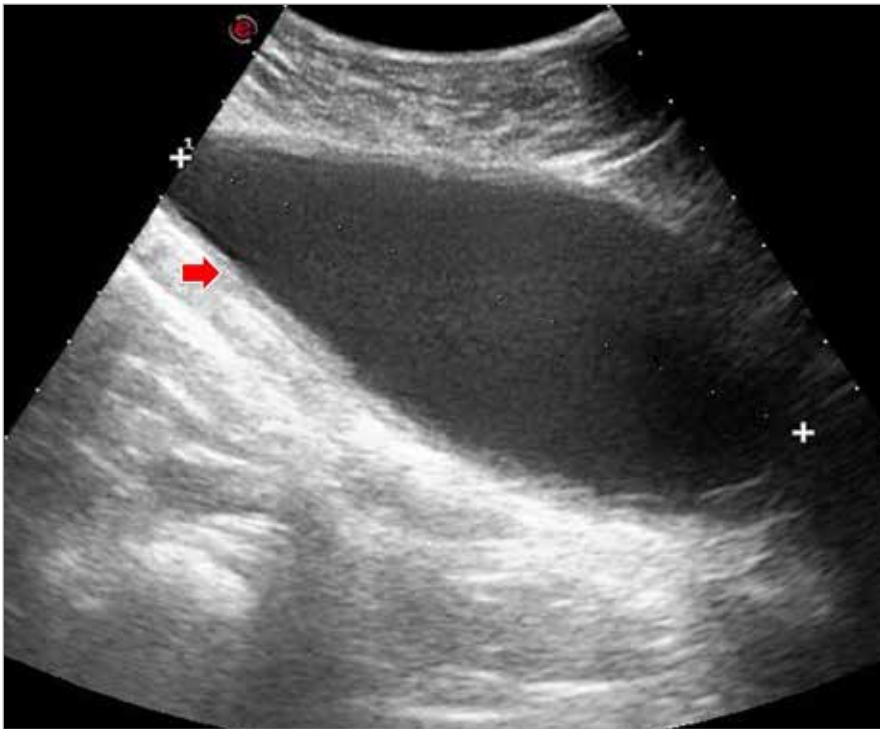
Ultrasound with liquid collection in the subcutaneous plane of 15 × 13 cm in the transverse direction and craniocaudal of 1.4 cm thick (red arrow).
